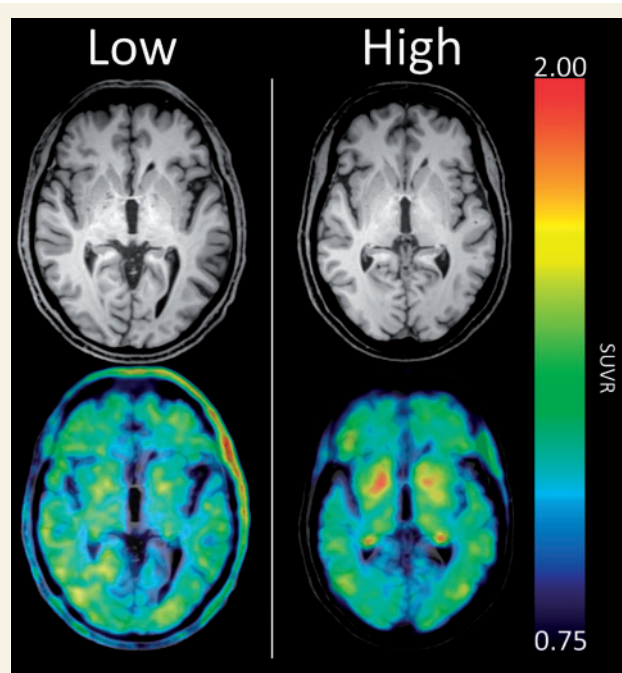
^{18}F -AV-1451 uptake in basal ganglia. Representative examples of low and high basal ganglia ^{18}F -AV-1451 binding. Left: 52-year-old male (SUVR 1.27); right: 71-year-old female (SUVR 1.53). Both are healthy controls. A 6 mm Gaussian smooth was applied to the PET images.
